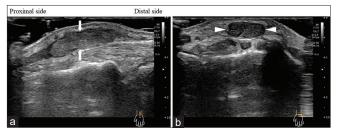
Ultrasonographic B-mode images showing a nodular echogenic mass in the cephalic vein on the dorsal aspect of the left wrist. (a) Longitudinal scan showed a homogeneous and hypoechoic mass (arrow). (b) Axial scan showed the same mass (arrowhead)
